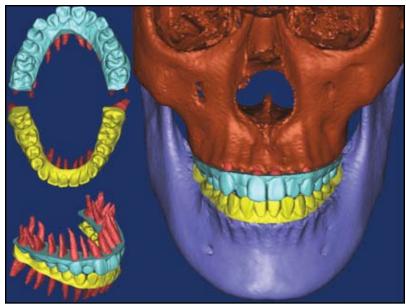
CBCT-based crowns eliminated from merged models; occlusal relationship generated by software.
